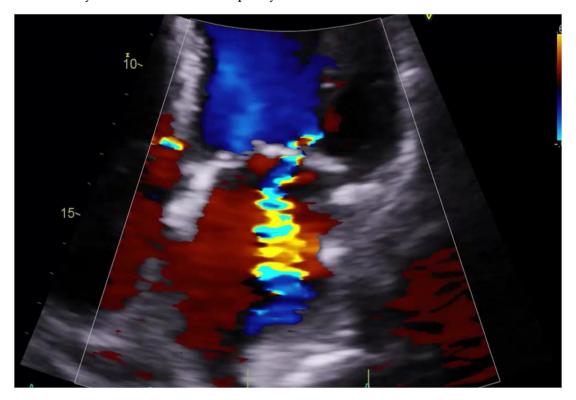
Echocardiogram-Apical four chamber showing turbulent flow through mitral valve.
